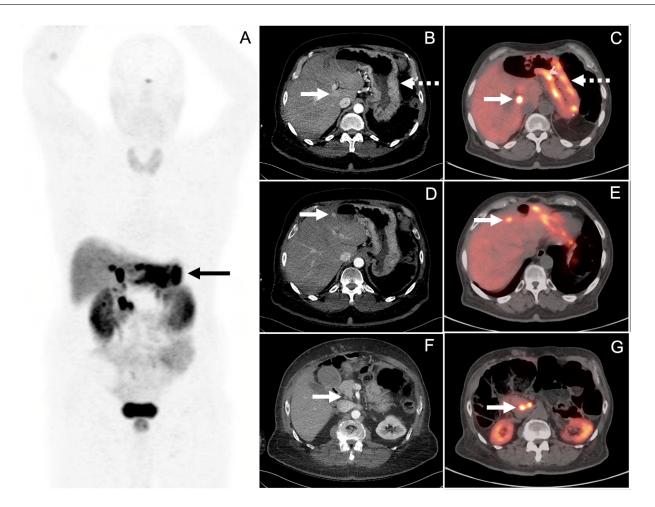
(A) Whole body rotating (MIP—multiple intensity projection) image from patient's Ga-68 DOTATATE PET/CT show intense uptake in the stomach (black arrow) and other foci in the upper abdomen. B and C are CT and fused PET/CT images showing multifocal to diffuse uptake in the stomach corresponding to heterogeneously enhancing mural thickening (dashed arrow). There is also focal uptake in a subtly enhancing hepatic metastasis (solid arrow). Images D and E show focal uptake in a small enhancing hepatic metastasis (arrow). Images F and G show focal uptake in subcentimeter lymph nodes at the level of the SMA.
